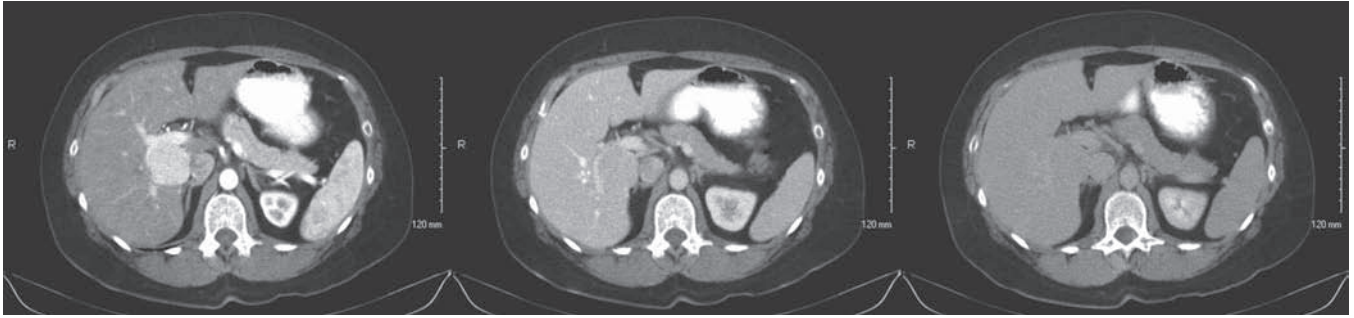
Computed tomographic appearance of hepatic adenoma of the right hemiliver. Note the rapid homogenous contrast enhancement seen on arterial phase images and rapid contrast washout seen on delayed images.
